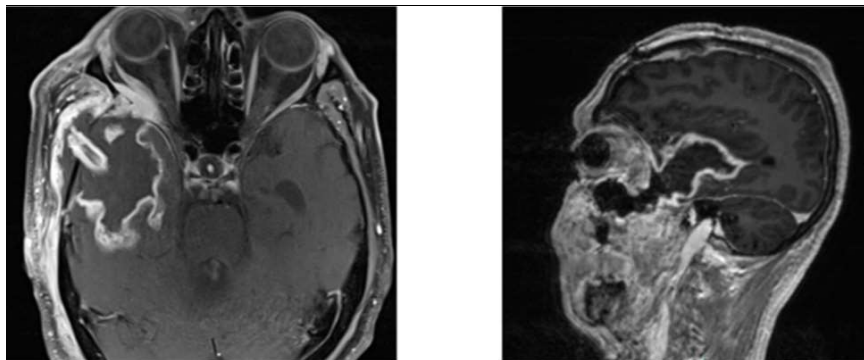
MRI Brain a) axial section of brain b) sagittal section brain showing expected post operative changes.
